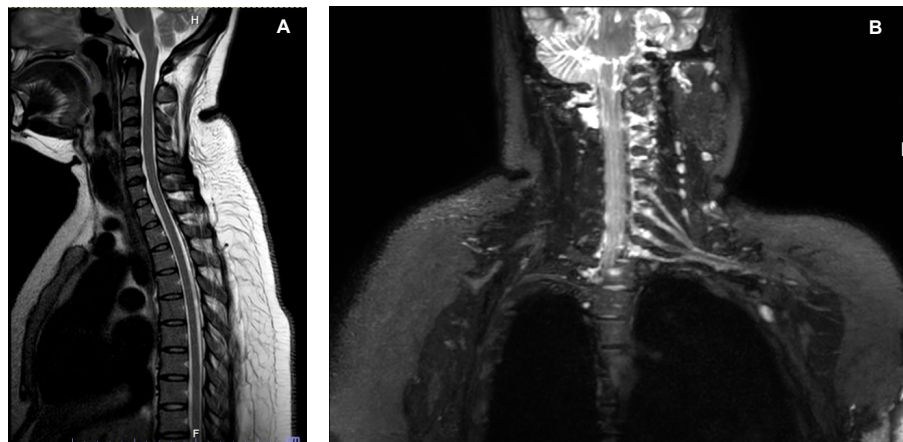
Magnetic resonance imaging (MRI) findings.
